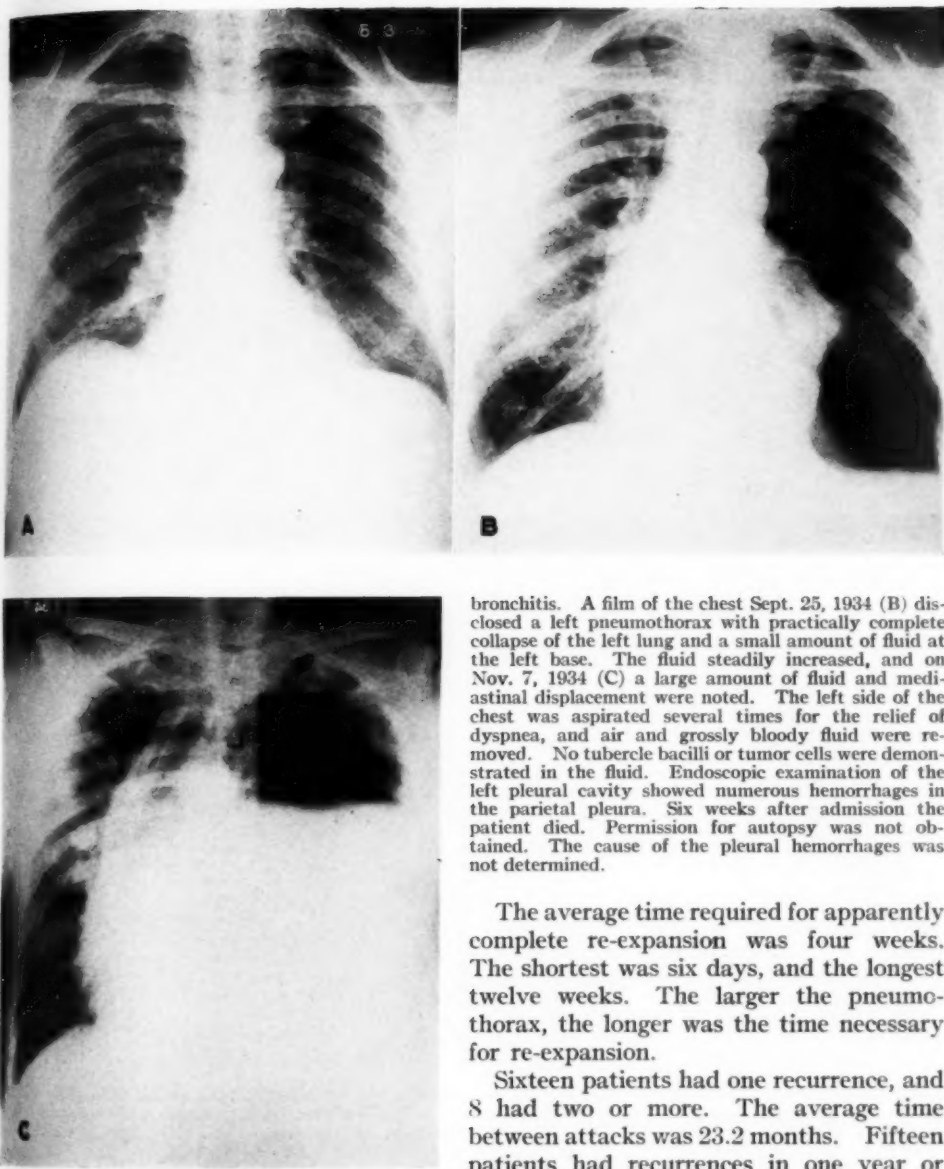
Spontaneous pneumothorax with hemothorax. A. Roentgenogram of chest taken on May 31, 1932; the patient complained of anginal pains. B. Spontaneous pneumothorax, left, Sept. 25, 1934, with practically complete collapse of left lung and a small amount of fluid at left base. C. Spontaneous pneumothorax with large collection of fluid and contralateral mediastinal displacement, Nov. 7, 1934.
